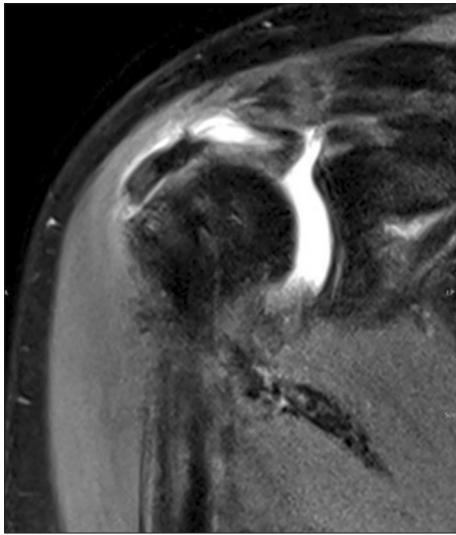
Coronal T2-weighted magnetic resonance imaging showing a tear of the transferred tendon following lower trapezius tendon transfer.
